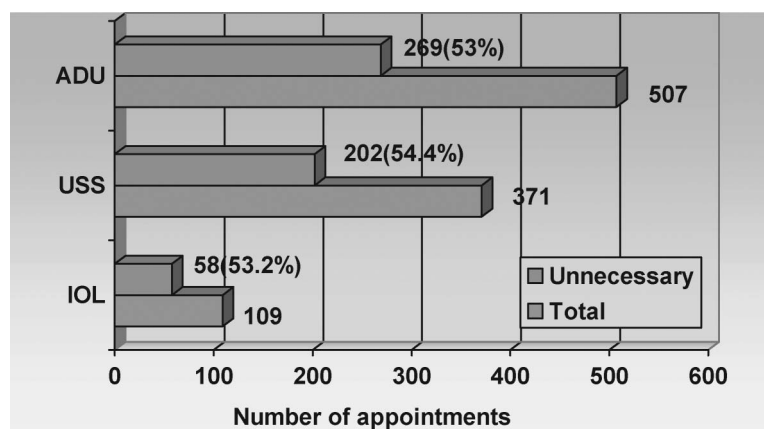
Interventions for IUGR. ADU, antenatal day unit; USS, ultrasound; IOL, induction of labour.
